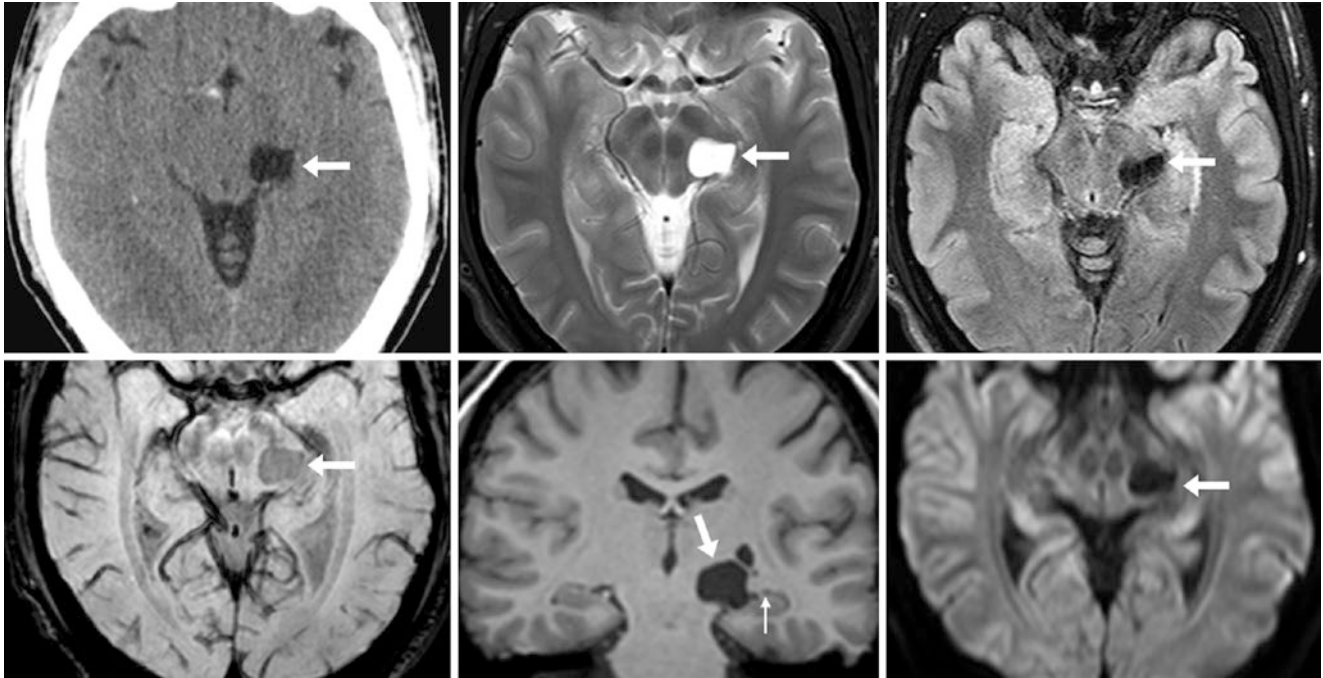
A 27 year old had a NECT (*top left*) after a fall, in which there was a cyst greater than 2 cm (*arrows*) with CSF density located in the lateral left midbrain. A 3T MRI two days later showed that the cystic lesion had CSF signal intensity on T2WI (*top middle*), FLAIR (*top*
